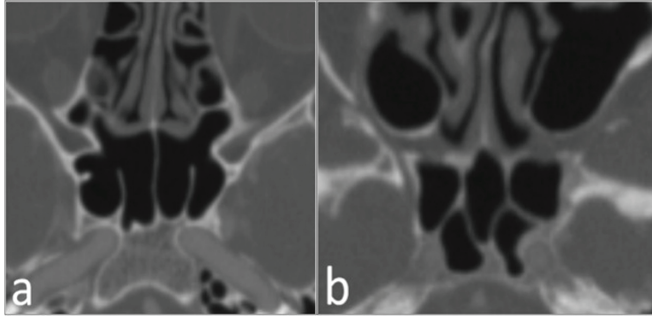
In (a), axial computed tomography angiography image of a case who has a detectable main septum is seen although there are three septa in the sphenoid sinus. In (b), although multiple septa are seen in sphenoid sinus as well, there is no detectable main sphenoid septum.
